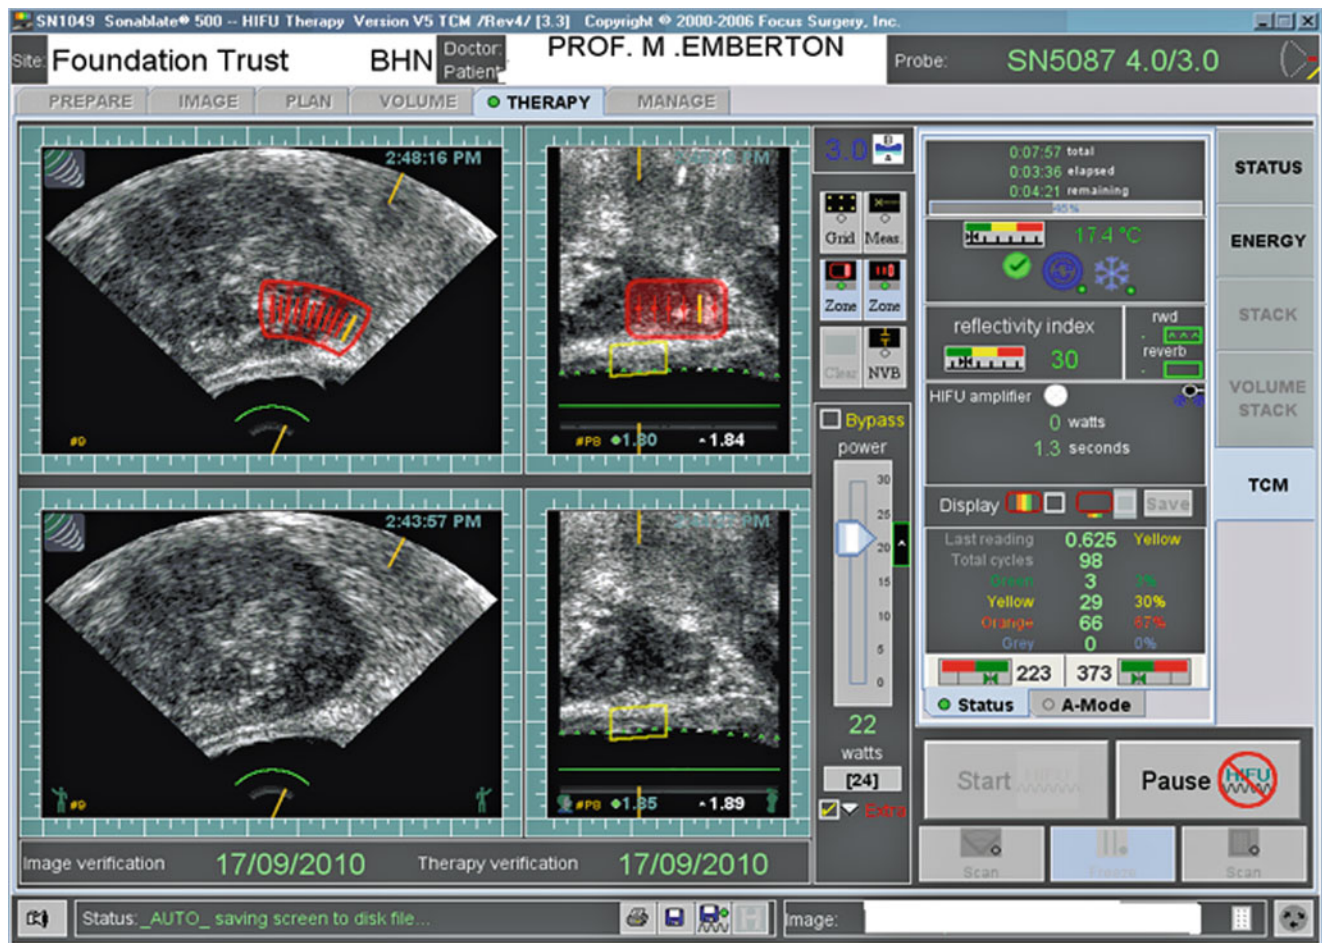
Ultrasound images of a focal HIFU treatment (Sonablate 500®). Live images are seen in the sagittal and transverse views, and power levels can be adjusted according to the visual effects seen
